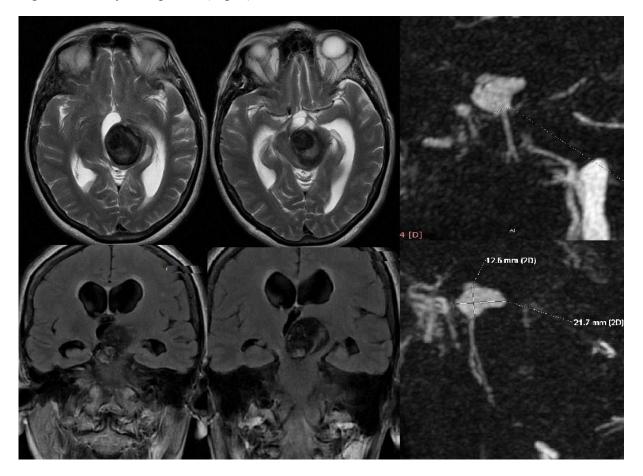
Axial (a, b) and coronal (c, d) T2-weighted and Fluid-attenuated inversion recovery (FLAIR) images demonstrating giant previously treated and partially recanalized aneurysm at the level of the basilar bifurcation. Time-of-flight (TOF) MR images (e, f) showing the width of the aneurysmal neck and the incorporation of the origins of both posterior cerebral arties
